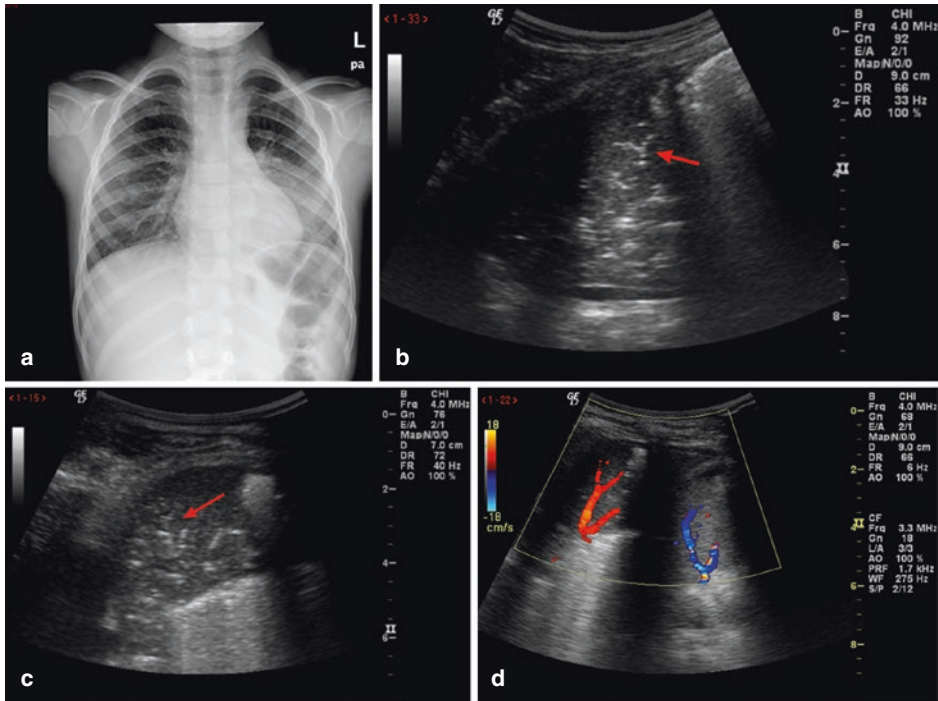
(a) plain radiography; (b–d) TUS
